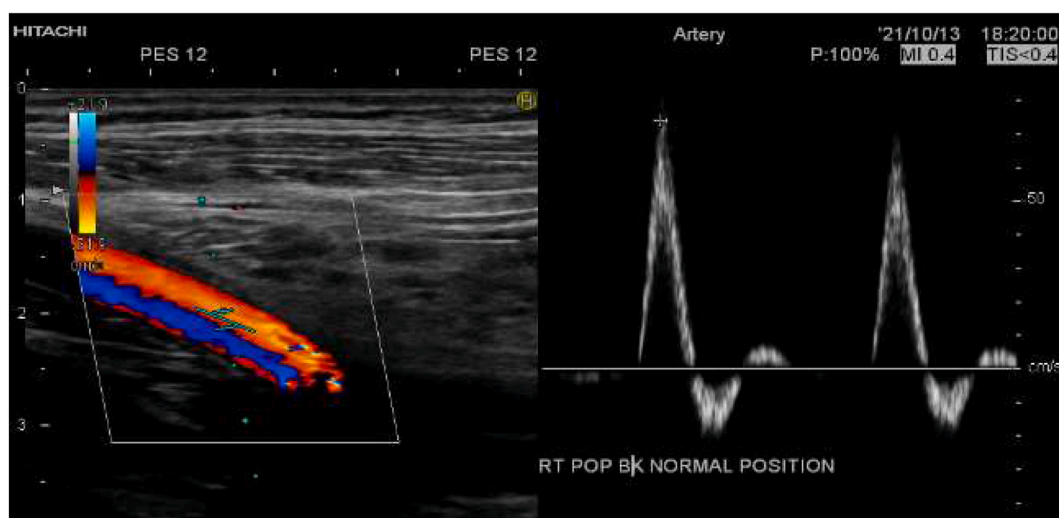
Duplex ultrasound image of the popliteal artery below the knee Doppler spectral.
